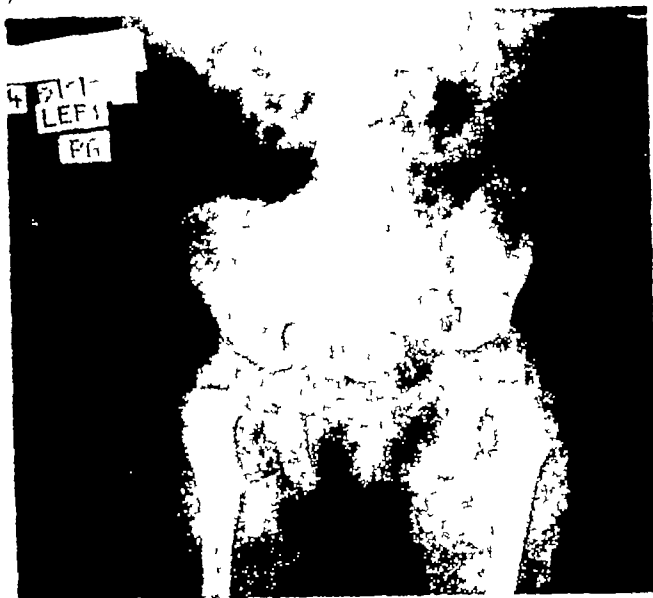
(Case R. W.) X-ray of two-year-old girl with anterior dislocation of left hip. Note deficient acetabulum, cervical torsion, lateral misplacement of capital epiphysis, and early osteochondritic changes (Legg's disease) This child had also a congenital equinovarus deformity of the left foot.
